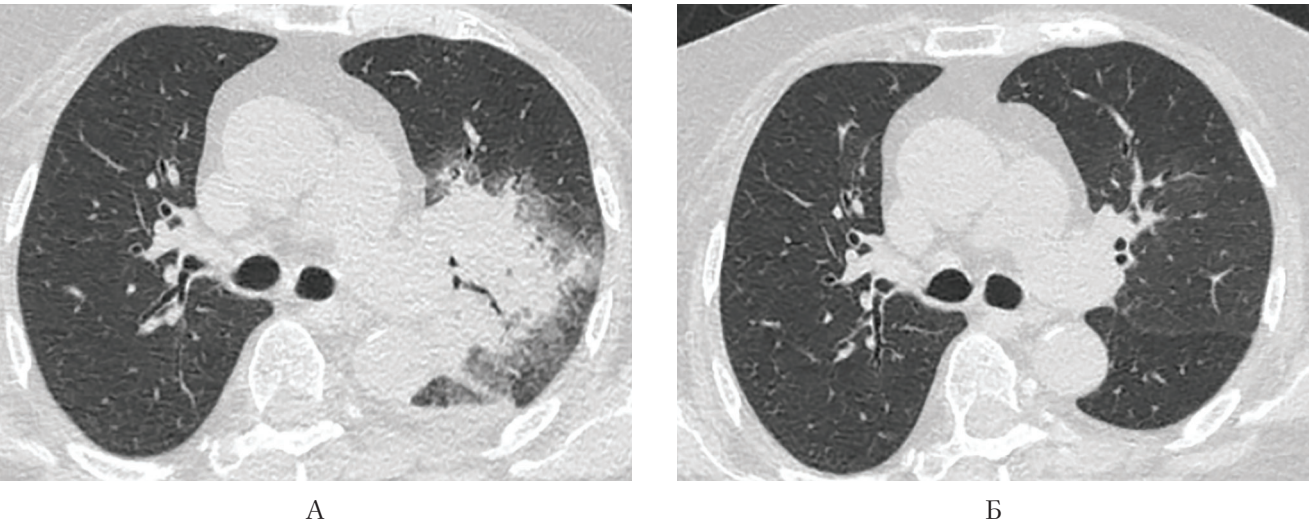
Regress of CT lesions in 79 y.o. patient with community acquired pneumonia
